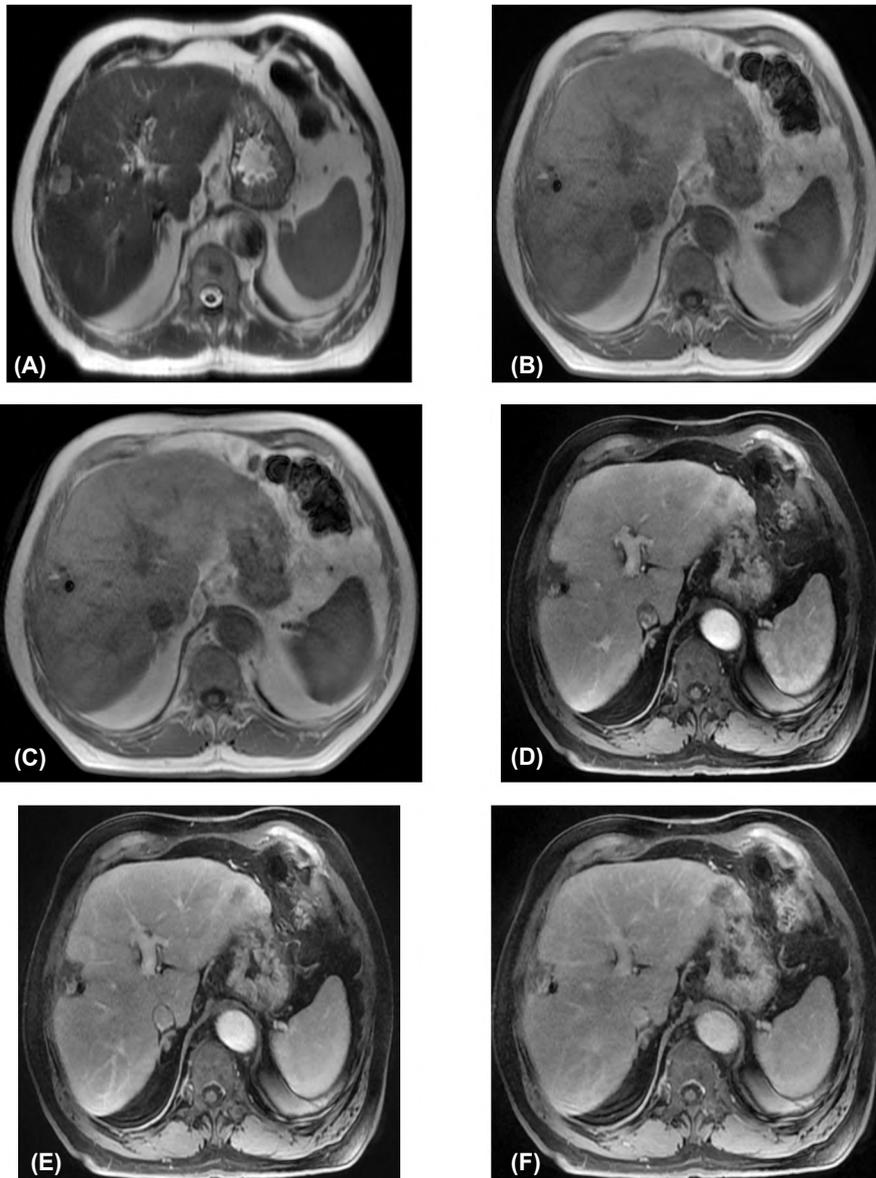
(E to N) Post-treatment DCE MRI with DWI following one month from TACE. (E, F) Axial and pre-contrast T1 images revealed faint dark signals of the chemo-embolized segment VIII lesion. (G) Late arterial phases of T1 image showed pathological arterial enhancement in most of its portions. (H, I) Porto-venous & delayed phases of T 1 showed evident washout of the previously arterial enhancement. (J, K) Late arterial & delayed phases of T1 LAVA with subtraction confirmed arterial enhancement with washout. (L, M, N) DWI (b-value 800) & corresponding ADC map images showed true diffusion restriction of the chemo-embolized lesion with ADC value of  $0.91 \times 10^{-3} \text{ s/mm}^2$ . Final diagnosis: Residual/recurrent H.C.C.
